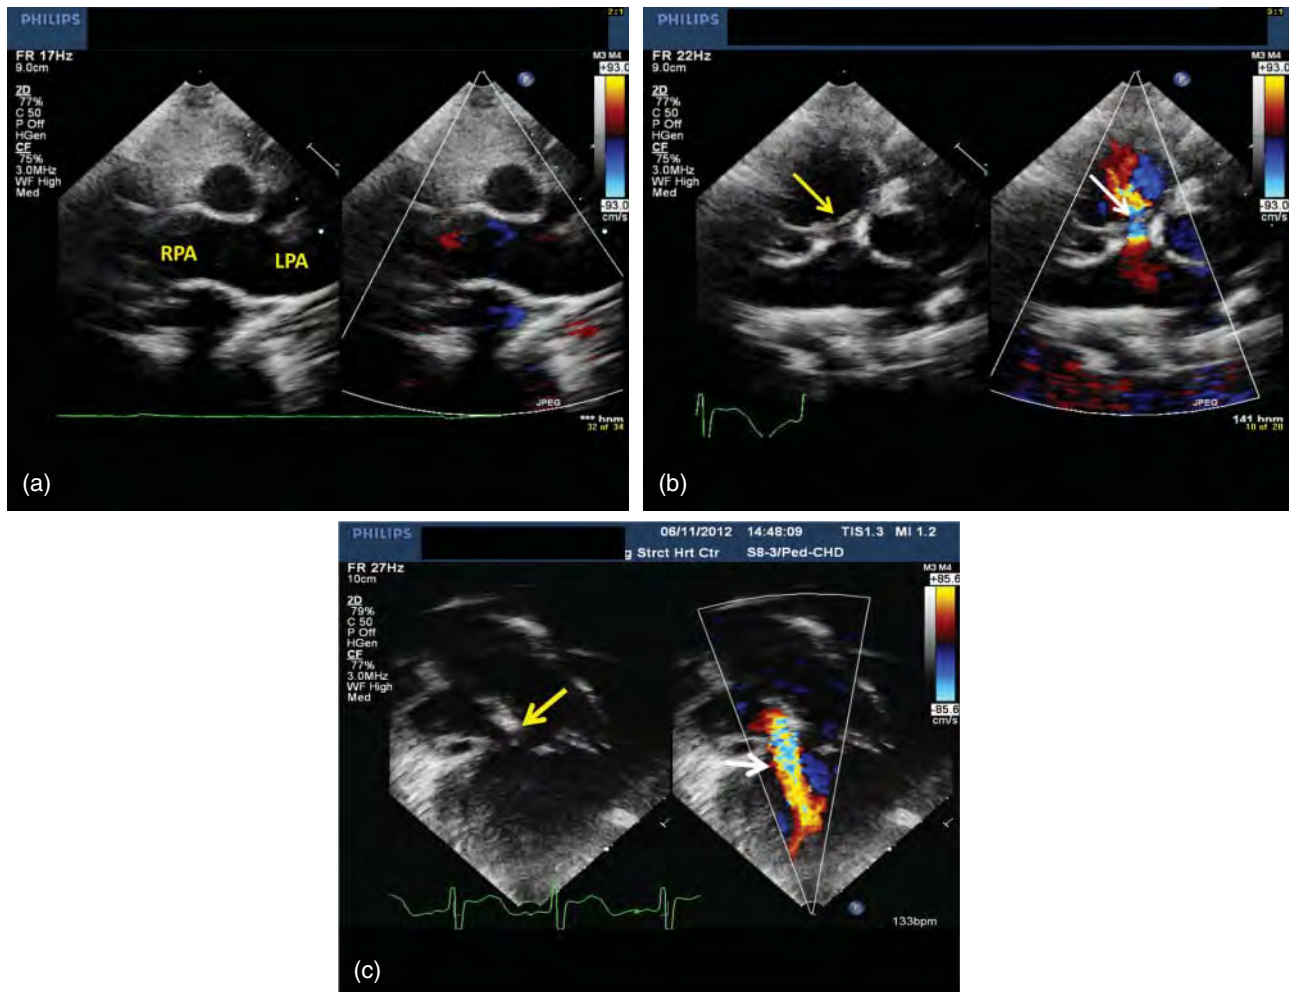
Postnatal transthoracic echocardiogram of a patient with visceral situs inversus, dextrocardia, and tetralogy of Fallot/absent pulmonary valve. (a) 2D and color image from high short parasternal view showing severely dilated branch pulmonary arteries. LPA, left pulmonary artery; RPA, right pulmonary artery. (b) 2D and color image from short parasternal view showing dysplastic pulmonary valve (yellow arrow) with turbulence of flow through the valve (white arrow). (c) Subcostal 2D and color image showing dysplastic pulmonary valve (yellow arrow) and significant pulmonary valve regurgitation (red color jet; white arrow).
